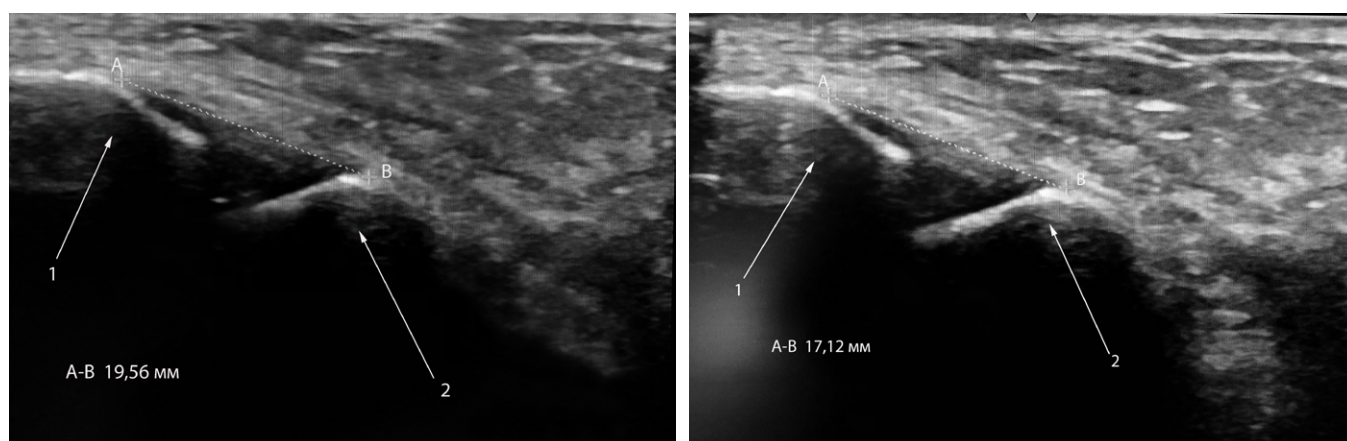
Length measurement of the anterior talus-fibular ligament in the position of the inversion stress test during sonography.
